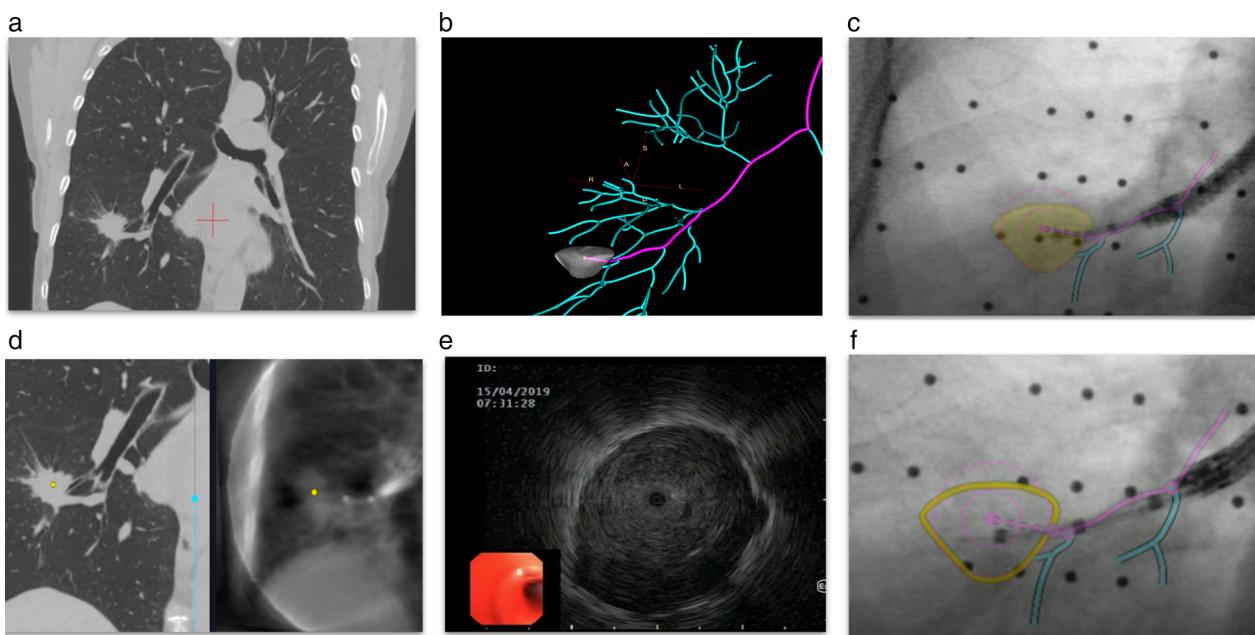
Procedure flow. PPN was identified on CT (a). A proposed navigation pathway was presented on the screen (b). The physician navigated with a steerable catheter through the working channel of the bronchoscope to the PPN with real-time augmented visualization of PPN (c). Once the catheter reached the proposed PPN location, localization was confirmed with CABT, showing that the catheter is at the PPN (d) as well as with RP-EBUS (e). Biopsies with different tools, including a cryoprobe, were collected under real time guidance from the PPN (f). PPN, peripheral pulmonary nodule; CABT, C-arm-based tomography; CT, computed tomography; RP-EBUS: Radial probe endobronchial ultrasound
